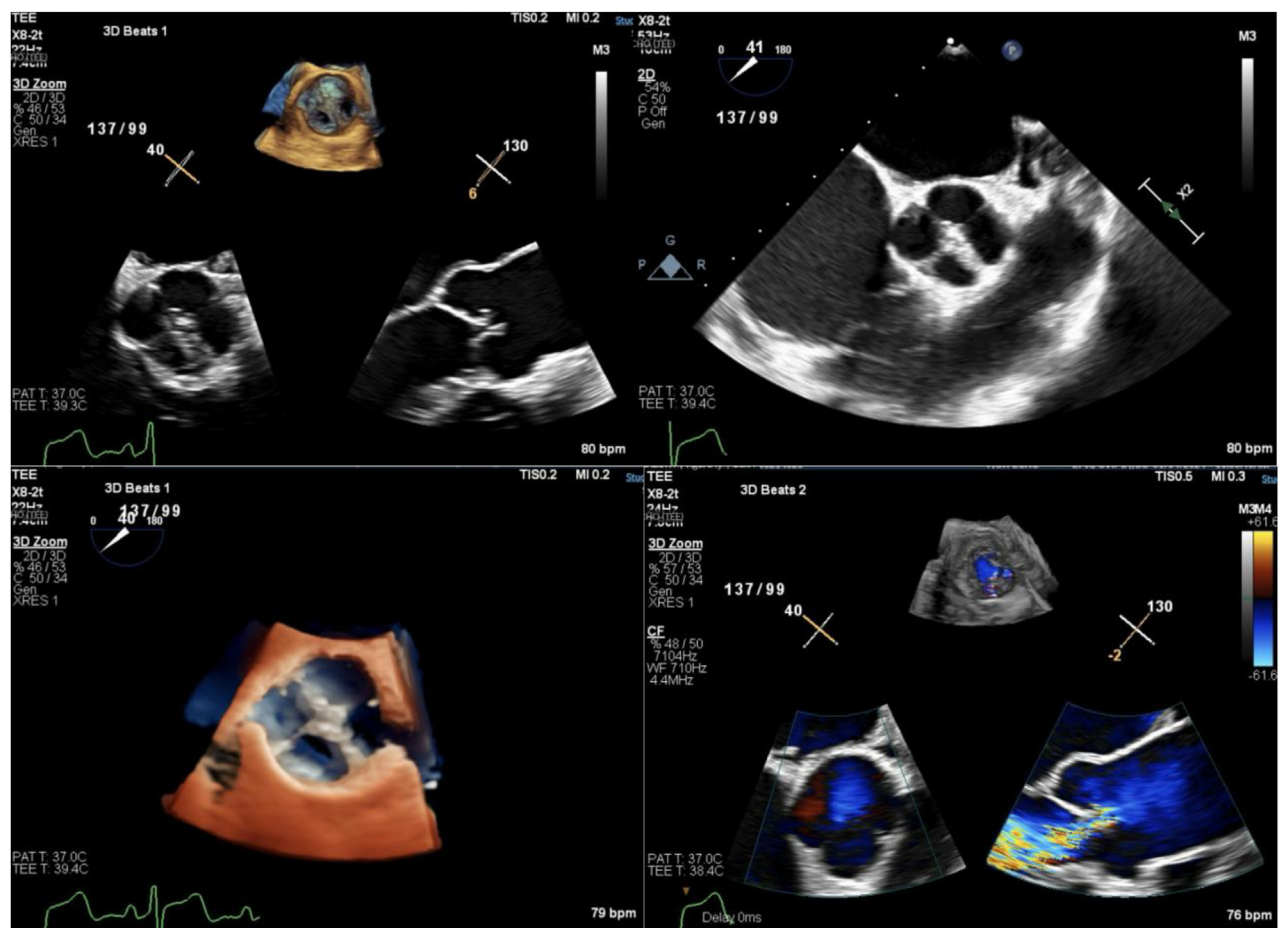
Case 2. Three-dimensional (3D) TEE, midesophageal simultaneous biplane short-axis (40°) and long-axis (130°) diastolic views with volume-rendered reconstruction en face diastolic display of the AV from the perspective of the aorta without (*top left*) and with (*bottom right*) color flow Doppler, two-dimensional TEE, short-axis (41°) diastolic view (*top right*), and 3D TEE en face diastolic photorealistic display of the AV from the perspective of the aorta (*bottom left*), demonstrate four distinct, focally thickened cusps characteristic of QAV and mild to moderate central AR (*bottom right*).
